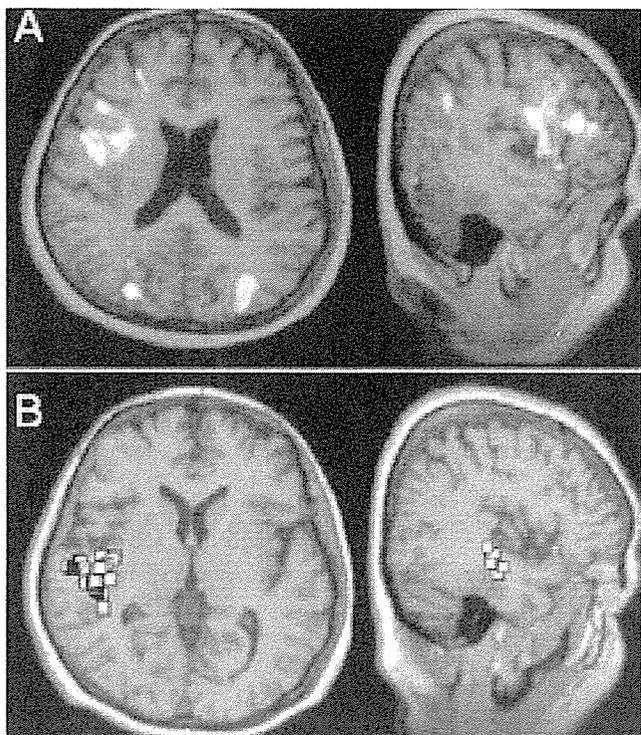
Case 21. A: right frontal lobe tumor in a 61-year-old, left-handed woman. A: Functional MR images obtained during a language task showing activation predominantly in the right IFG and the inferior part of the MFG. B: Magnetoencephalography source localizations obtained during a language task, superimposed on MR images, showing dipole clusters predominantly in the right STG and MTG. The left and right hemispheres contained 37 and 127 dipoles, respectively.
